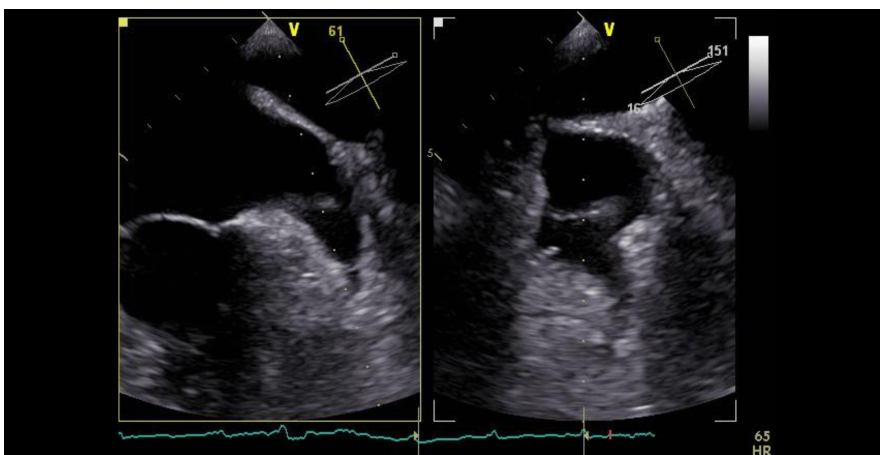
Transesophageal segmental sweep analysis of the left atrial appendage (LAA) with 2D xPlane imaging. These two perpendicular anatomic planes demonstrate a floating hyperechogenic structure in the middle part of the LAA without evidence of appendage wall adhesion.
